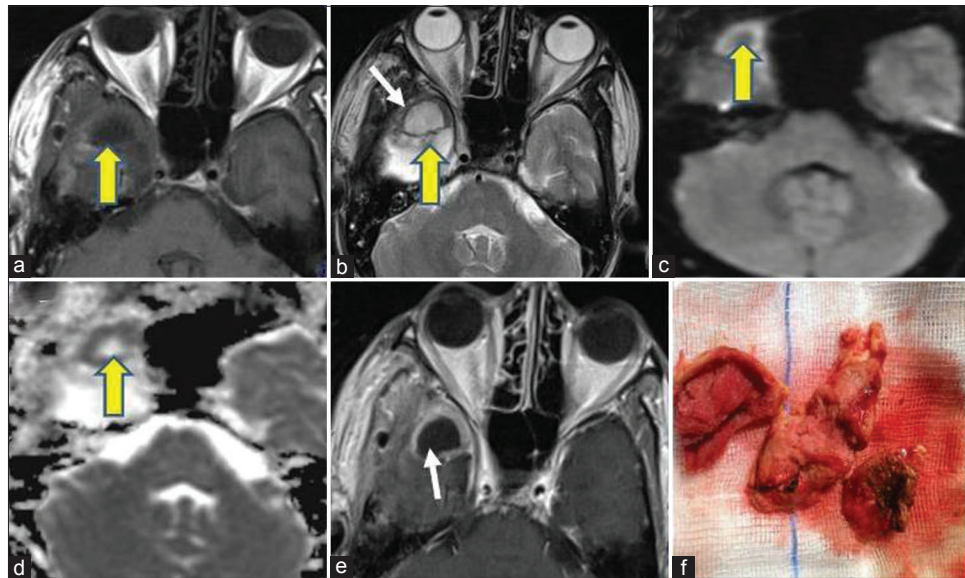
Case 1: (a) Axial T1-weighted image showing another rounded mass in right temporal lobe (yellow arrow) which is hypointense and surrounded by iso- to hyper-intense rim. (b) T2-weighted image shows hyperintense core surrounded by hypointense rim (thin white arrow). (c and d) On diffusion weighted image and corresponding ADC, the core of the lesions does not show diffusion restriction. (e) Contrast was administered and it shows prominent peripheral enhancement in the lesions (thin arrow). (f) Intraoperative image showing gauzoma
